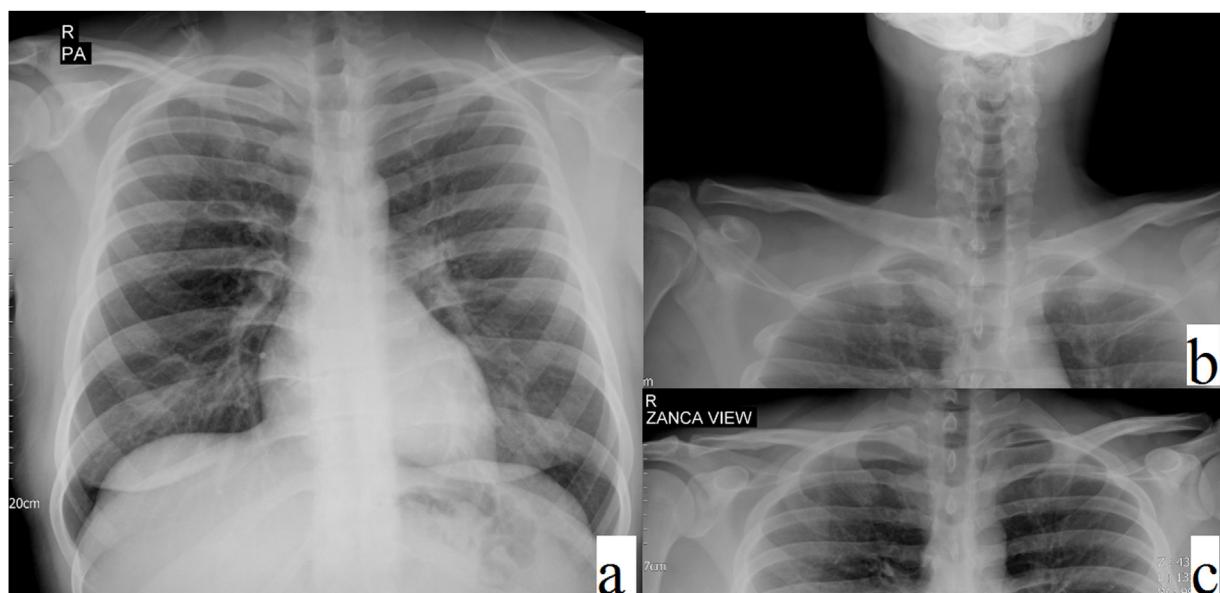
Initial radiographies including chest X ray (a), Serendipity (b) and Zanca view (c) of our patient demonstrated a superior dislocation of the right sternoclavicular joint.
